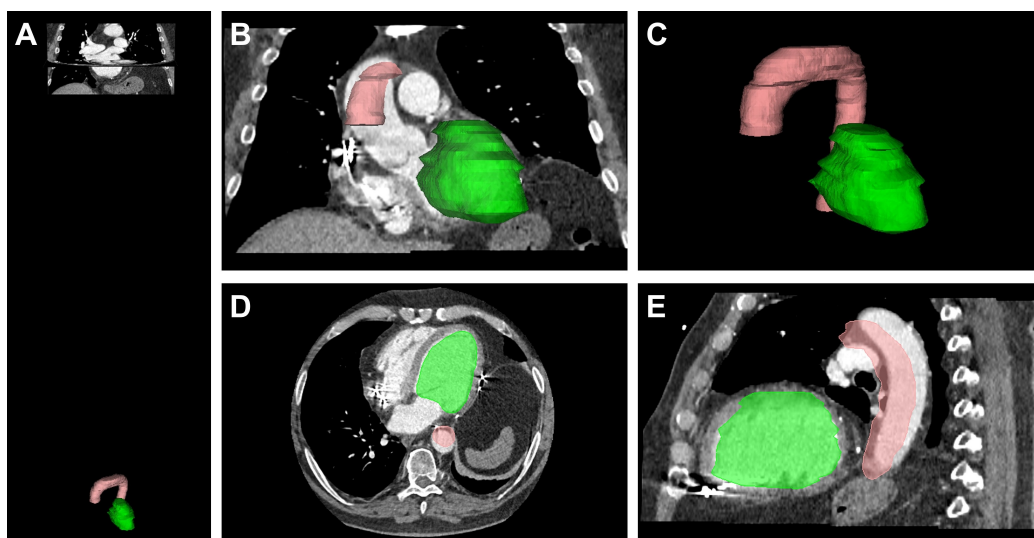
Representative case of the rigid registration between the cardiac computed tomography (CT) and planning CT. Green: left ventricle (LV); pink: aorta. (A) Visualization of the LV and aorta structures in coronal view of the cardiac CT before registration. (B) Visualization of the LV and aorta structures in coronal view of the registered cardiac CT. (C) Visualization of the LV and aorta structures in the 3D view. (D) Visualization of the LV and aorta structures in axial view of the registered cardiac CT. (E) Visualization of the LV and aorta structures in sagittal view of the registered cardiac CT.
